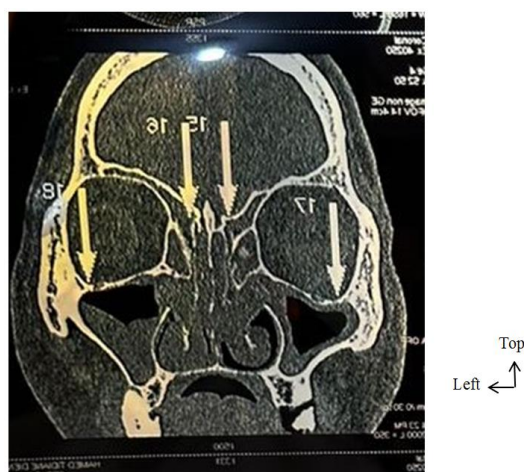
CT scan of the facial mass: axial section.
